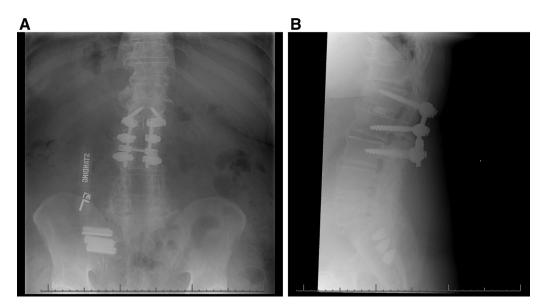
A, 7B Post-operative AP (7A) and Lateral (7B) view radiographs demonstrating intact hardware without evidence of failure.
